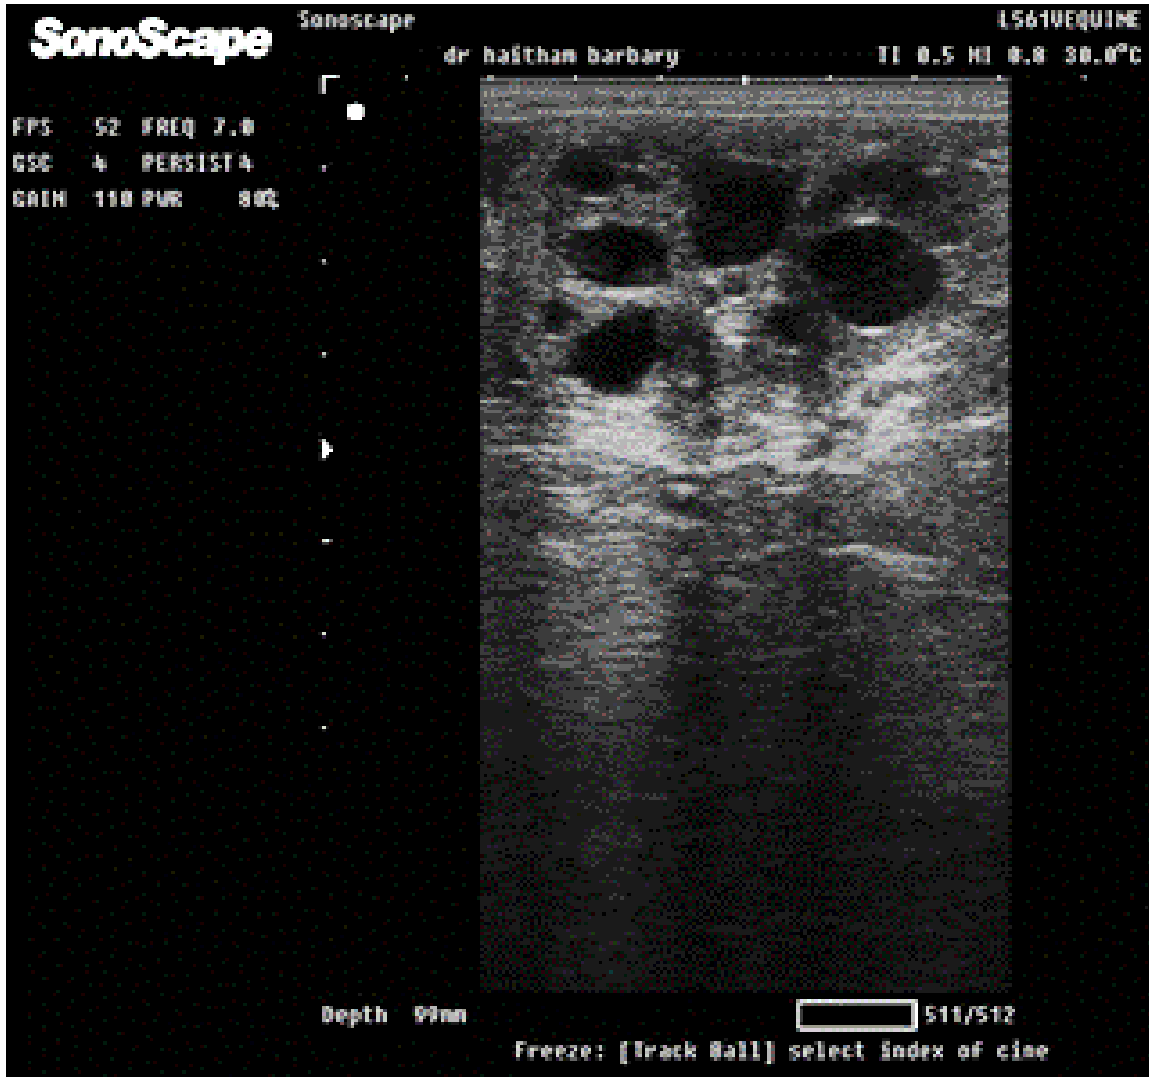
Ultrasonographic image of kidney shape ovary containing small follicles
